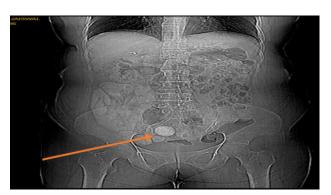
Plain abdominal radiograph (erect view) showing a discrete, radiopaque shadow in the right lower quadrant (arrow), suggestive of a calcified intraluminal mass consistent with an enterolith.
